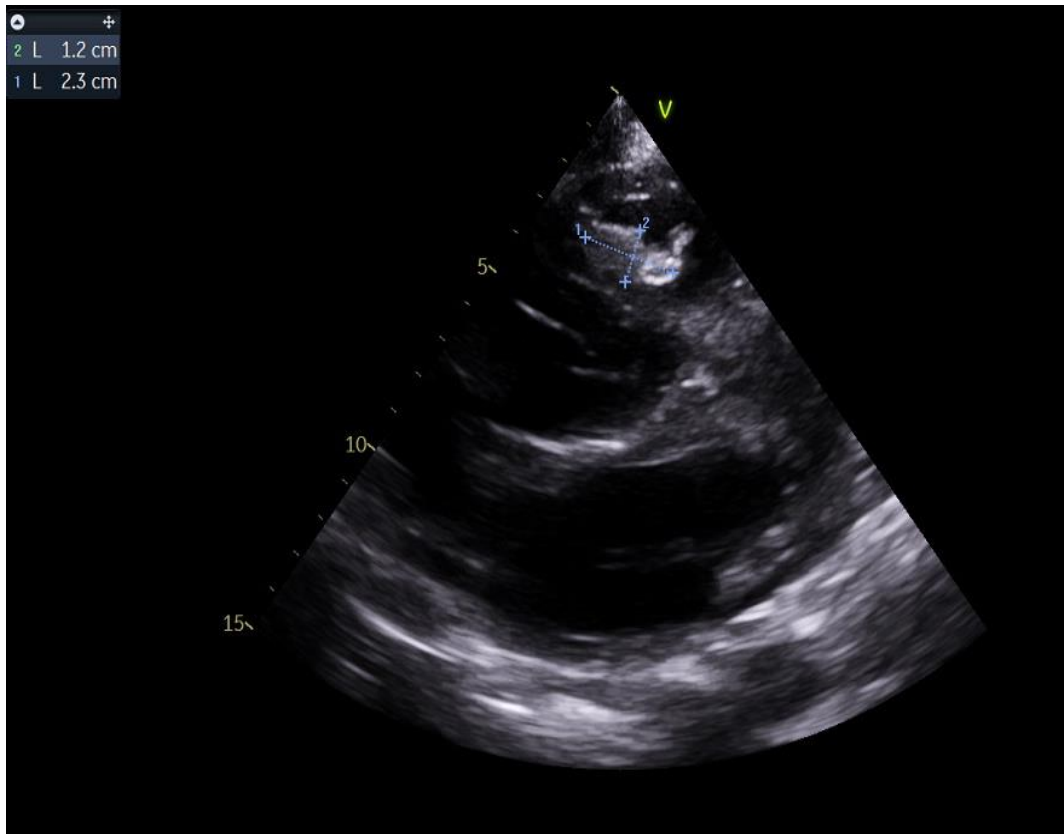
Modified parasternal long axis view showing a hyperechoic filiform image arising on the IVS and floating in the RV (vegetation image)
